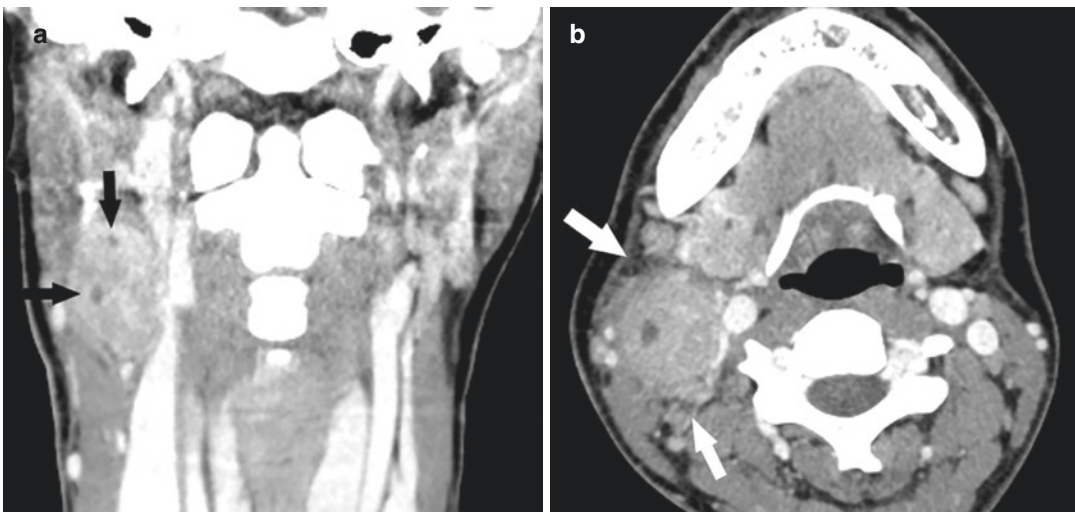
Necrotic cervical lymph node in Kikuchi disease. (a) Coronal contrast-enhanced CT image shows multiple indistinct necrotic foci within an enlarged lymph
